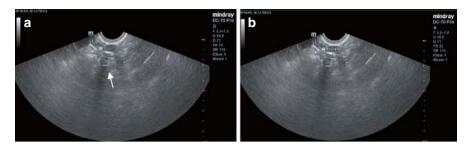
(a) Ultrasound image of normal ovarian reserve in a patient with craniopharyngioma. (b) Measurement of ovarian size
